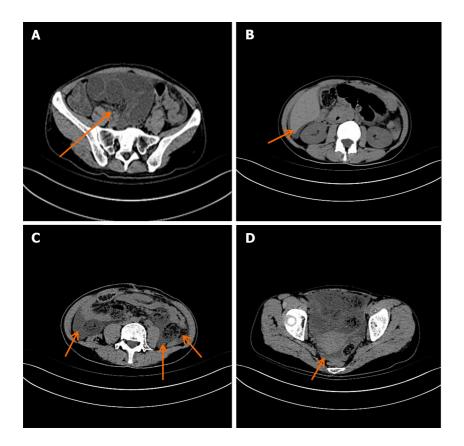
Representative whole-abdominal computed tomography images. A: Significant dilation and fluid accumulation of the bowel; B: An arc-shaped hypodense shadow under the capsule of the liver at the point indicated by the arrow; C: Fluid accumulation in abdominal cavity by the arrow; D: Fluid accumulation in pelvic cavity by the arrow.
